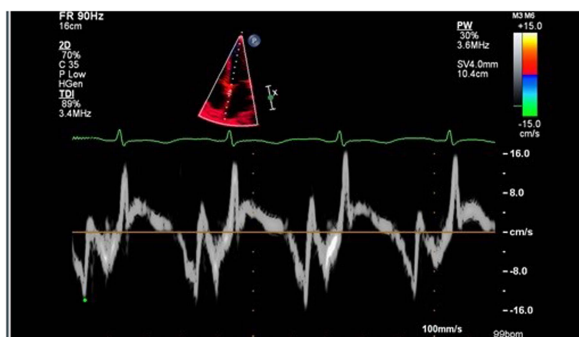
Annulus paradoxus. Tissue Doppler showing increased septal 'e' velocity of 13.7 cm/s.
